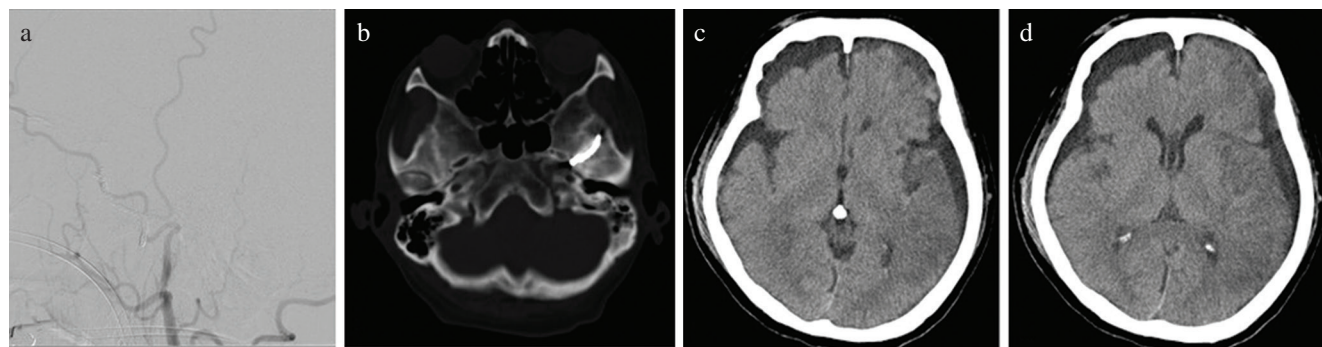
(a) Transarterial coil embolization of the fistulous point and main trunk of the middle meningeal artery (MMA) was performed uneventfully. Left external angiography demonstrated good obliteration of the AVF. (b) Postoperative computed tomography (CT) (bone window) showed coil materials lining the main trunk of the MMA near the foramen spinosum. (c and d) Follow-up CT showed residual low-density area in left hemisphere. AVF: arteriovenous fistula.
